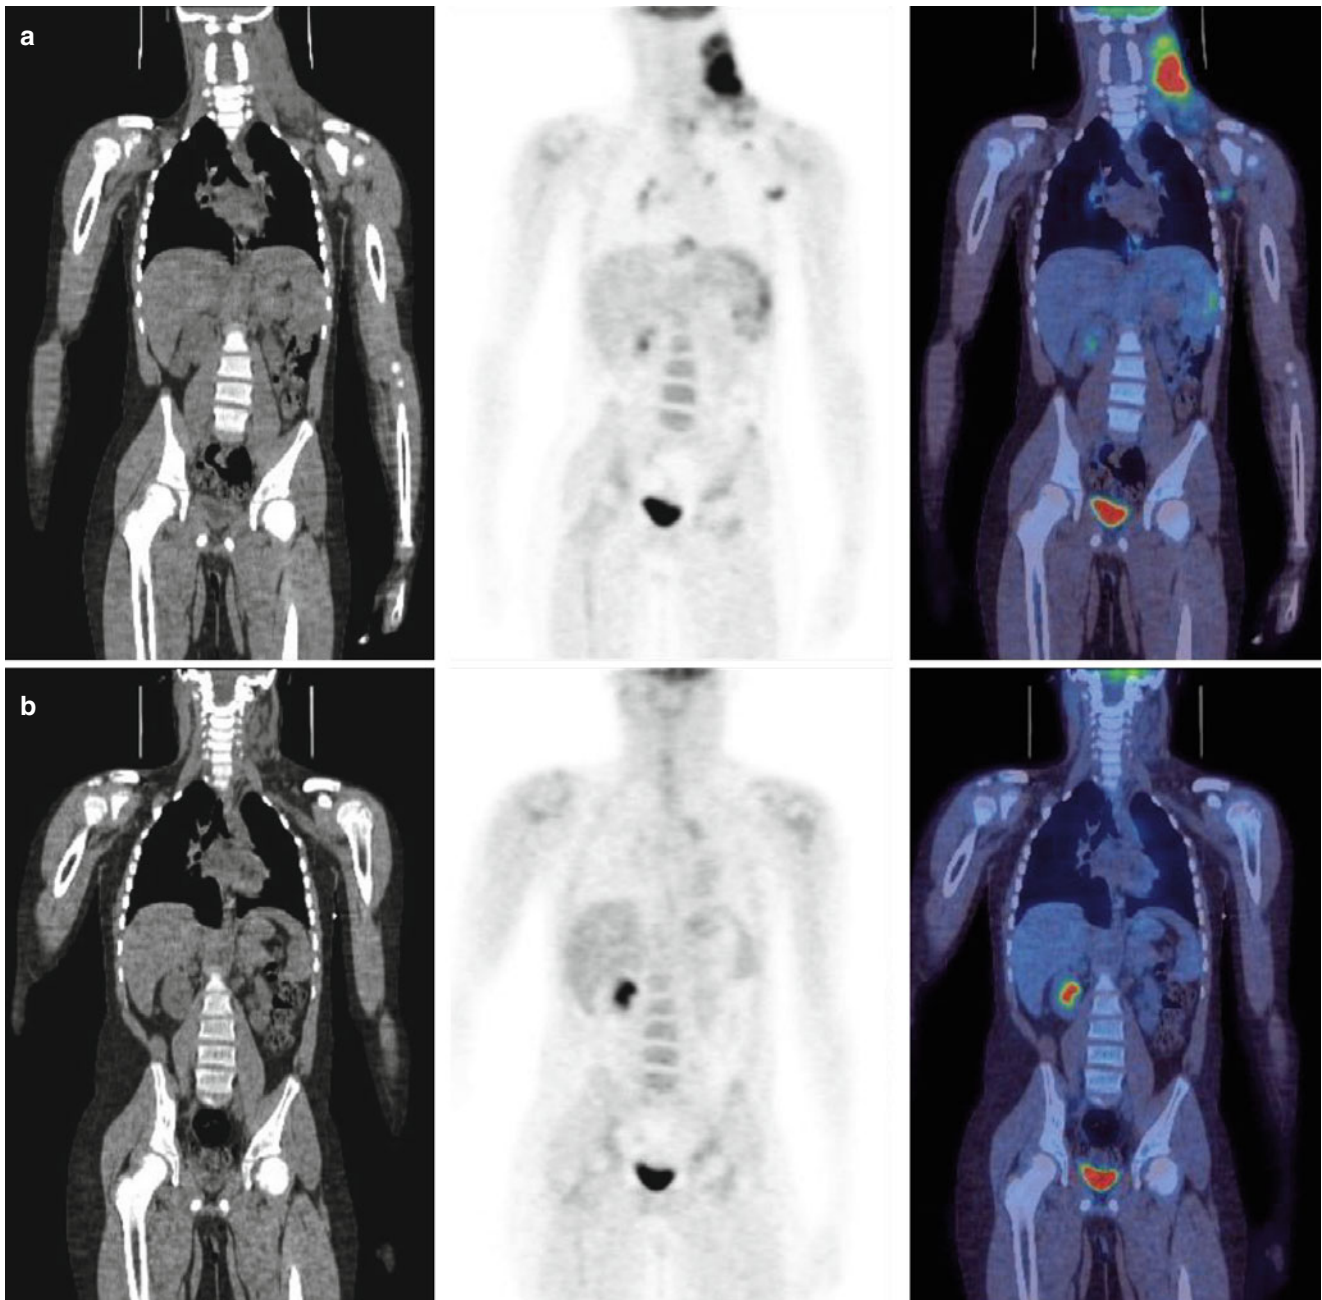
Mediastinal disease in lymphoma. An FDG-PET image is acquired simultaneously with a low-dose CT, which are then fused together. In this example, disease in the neck and mediastinum show a
